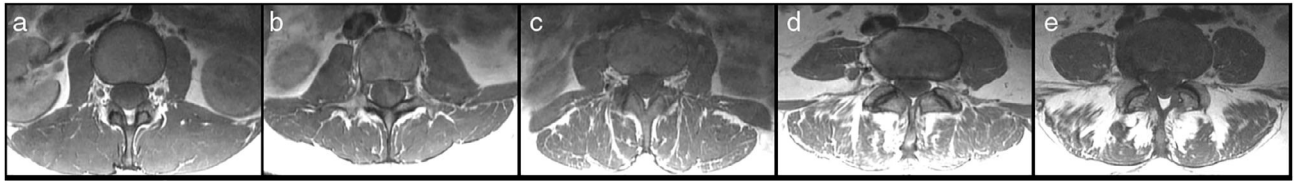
Goutallier classification (GC) for paraspinal musculature (PSM). Representative axial T1-weighted fast spin-echo (FSE) images for the different GC scores: 0—normal muscle (a); 1—some fatty streaks (b); 2—less than 50% fatty muscle atrophy (c); 3—50% fatty muscle atrophy (d); and 4—greater than 50% fatty muscle atrophy (e).
